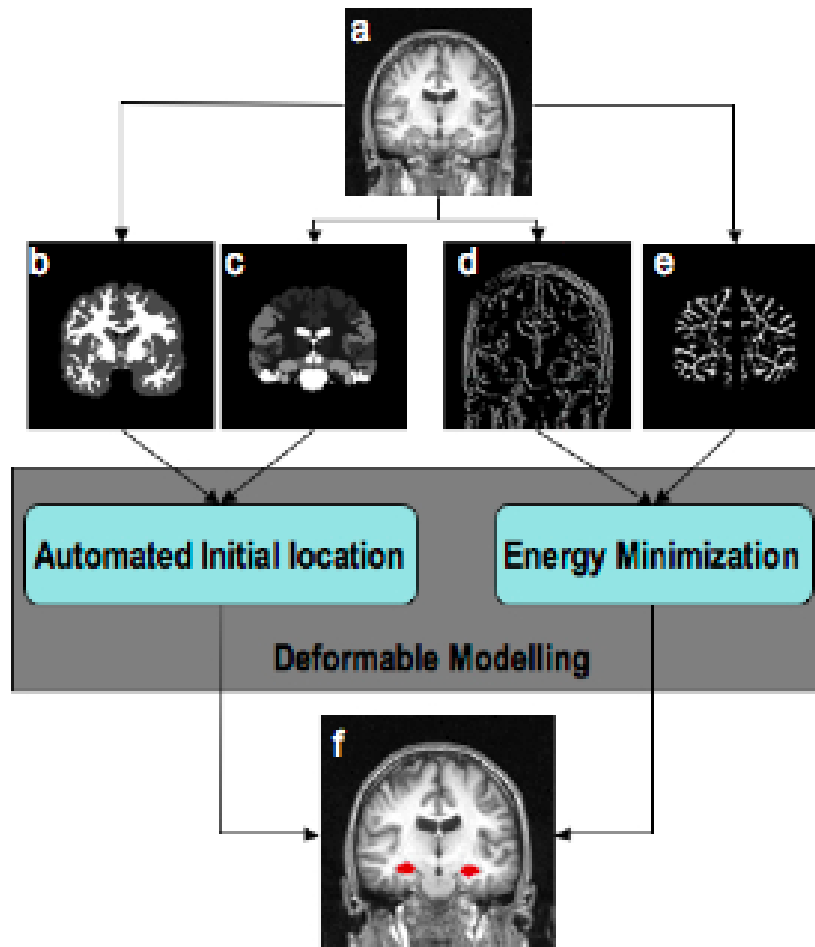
A graphical representation of the input required at each stage of the methodology. (a) is the original MRI scan, (b) is the threshold map, (c) is the warp map, (d) is the edge map, (e) is the sulcal ridge map and (f) is the final resultant map with the segmented hippocampi represented in red.
